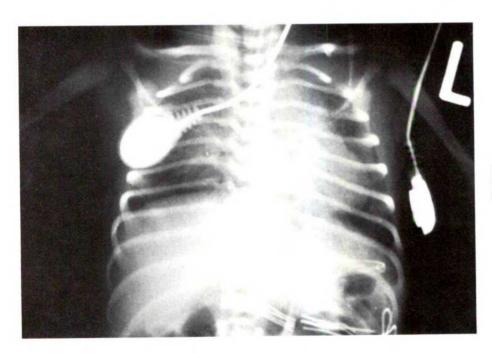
Chest X-ray film during TLV after withdrawal of the tracheal tube above the carina.
